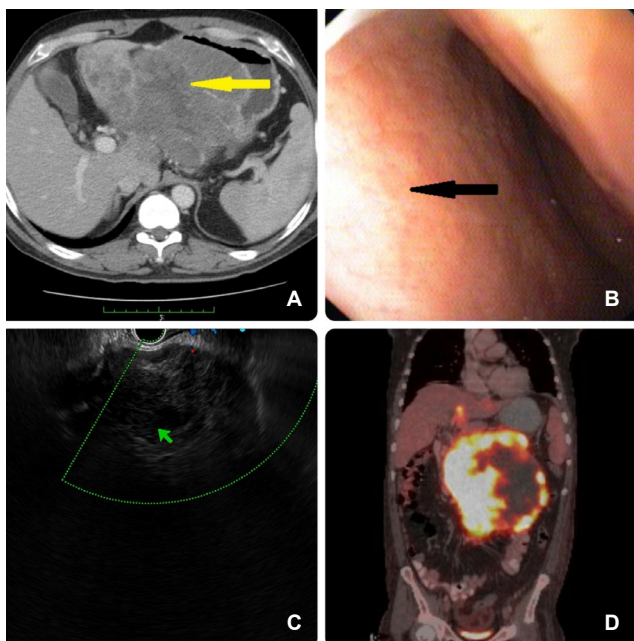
A) CECT image showing a large lobulated mass in the lesser sac, adjacent to the stomach. B) Endoscopic image showing a large mass causing luminal narrowing with normal mucosa. C) Endoscopic ultrasonography showing a large para gastric mass. D) PET/CT image showing hypermetabolic, large, exophytic growth from the stomach, and liver metastasis with no other lesions
